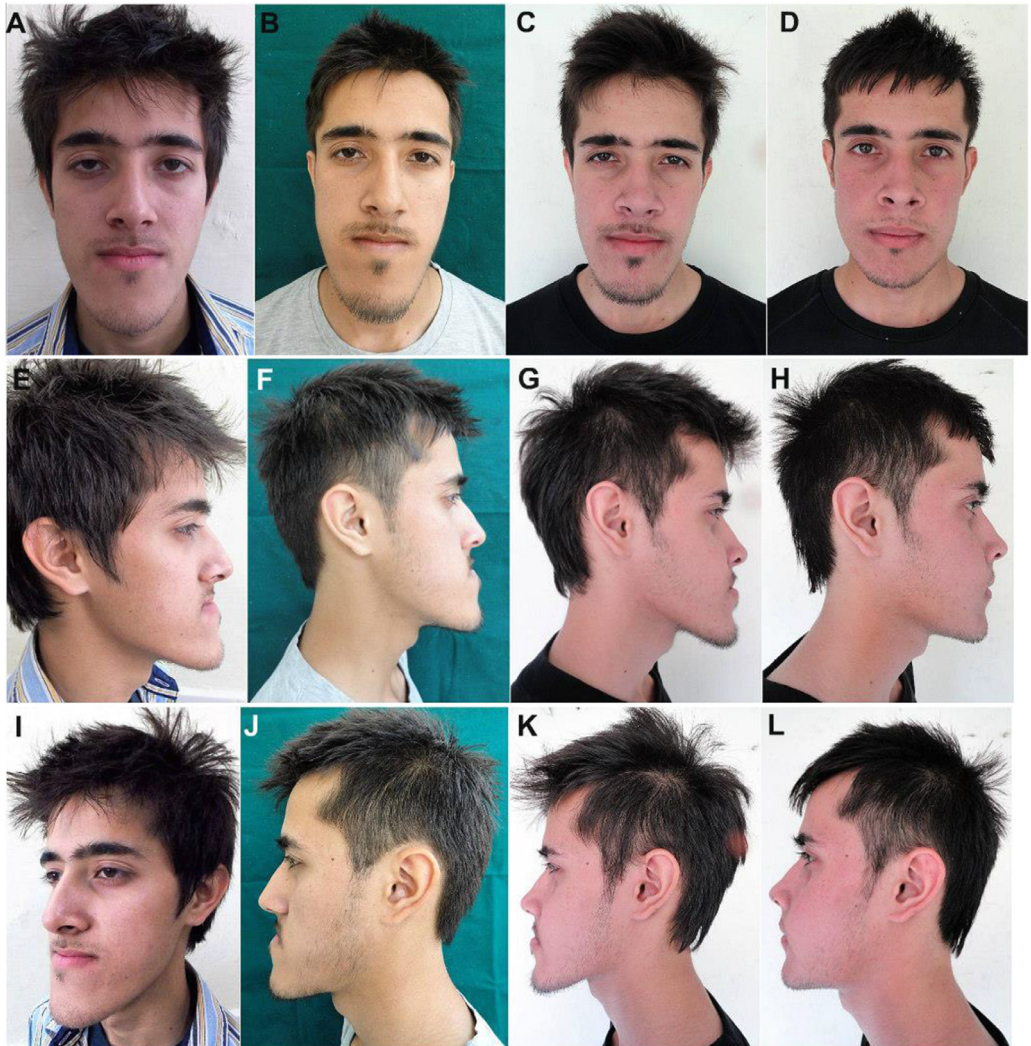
Comparison of Pre-treatment, Post-Presurgical Orthodontics, Post-Maxillary advancement and Post- Mandibular setback phases of management. (A-D) Frontal face photographs upon presentation; following presurgical orthodontics, following the first surgical phase of maxillary advancement and following the second surgical phase of mandibular setback. Achievement of an excellent esthetic outcome, facial balance and symmetry. (E-H) Right Profile view prior to treatment, following presurgical orthodontics, following maxillary advancement and following mandibular setback, showing correction of the markedly concave profile to a normal appearing and aesthetically pleasing mildly convex one. (I-L) Left Profile view upon presentation, after presurgical orthodontics, after Maxillary advancement and after Mandibular setback phases, demonstrating the severe facial deformity owing to an excessively concave profile and increased lower anterior facial height, and its successful correction to an aesthetically appealing and balanced profile with ideal facial proportions. (M-P) Extreme reverse overjet of 16 mm, reduced after first phase of Maxillary advancement by 9mm, corrected to a normal positive overjet of 2 mm following second surgical phase of Mandibular setback of 9 mm, and demonstrating stable results with nil relapse after two year's follow up. (Q-T) Lateral Cephalograms prior to treatment, following the Maxillary advancement phase, Mandibular advancement phase, and two years following treatment demonstrating successful correction of the facial deformity and stability of results achieved with nil relapse after 2 years of follow up. (U-X) Orthopantomograms before and after each phase of treatment, demonstrating the fixation implants in situ.
